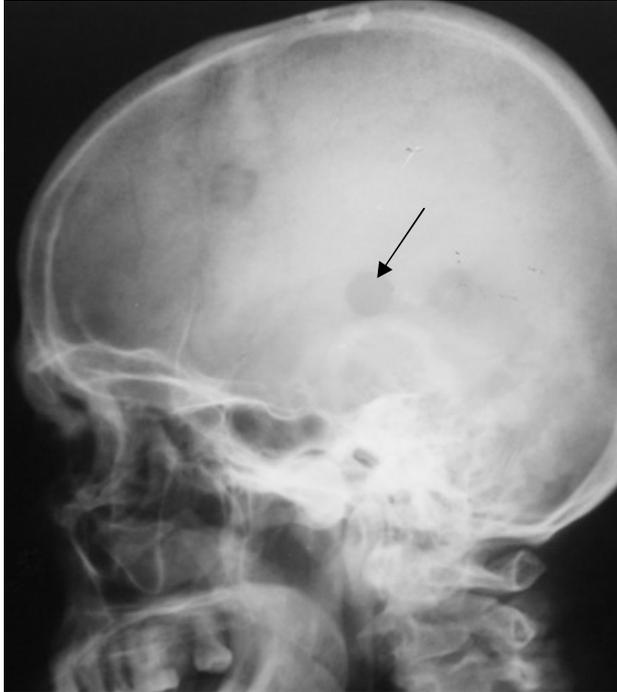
The survey radiograph of the skull in a lateral projection. Sites of destruction have roundish form with accurate contours in bones of the skull arch (arrow). Myeloma (a tumour derived from cells in bone marrow).
